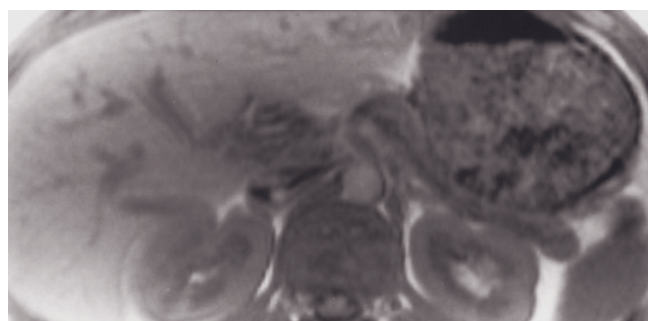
Chronic pancreatitis. Contrast-enhanced CT (a) T1-weighted fat-suppressed spin-echo (b), and immediate postgadolinium
